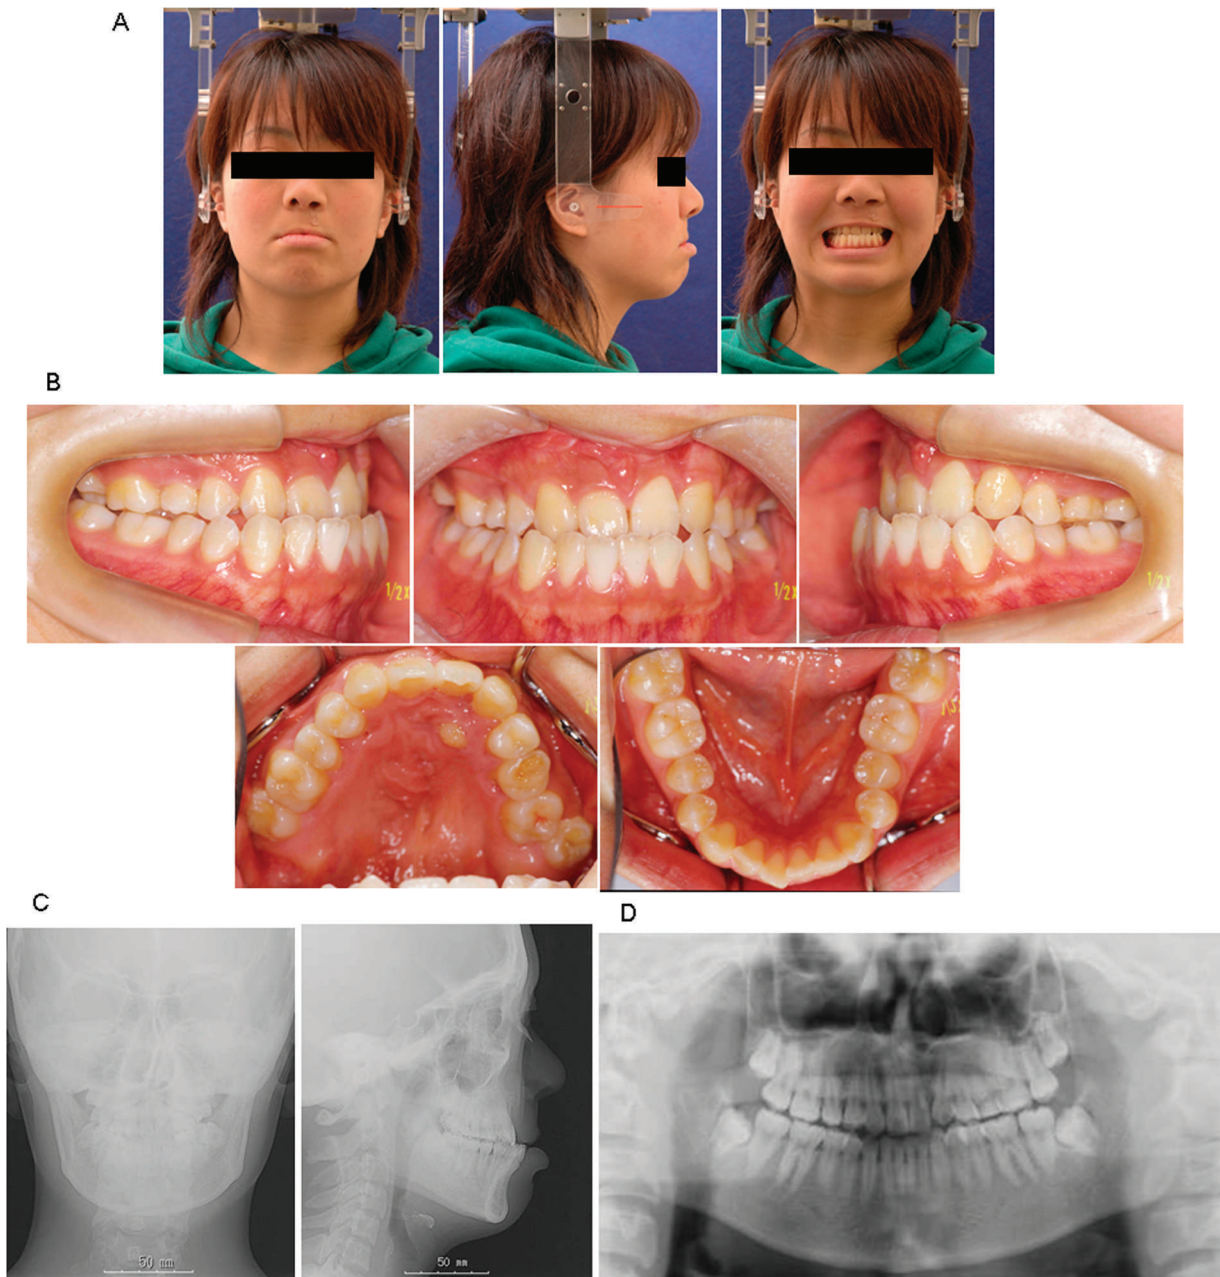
Pretreatment records (age, 17 years 11 months). (A) Facial photographs. (B) Intraoral photographs. (C) Frontal and lateral cephalograms. (D) Panoramic radiographs.
